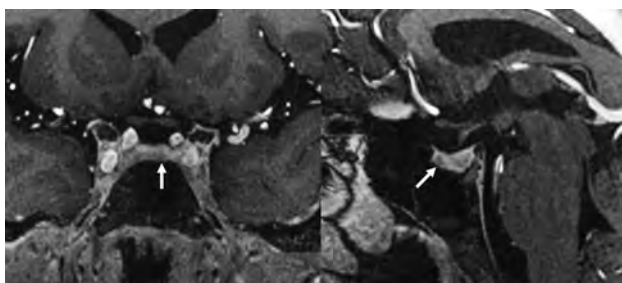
An example of 7T MR imaging showing a nondiscrete lesion (arrows) in the left paramidline pituitary gland on postcontrast MPAGE T1-weighted imaging at 0.33 mm that was a pathology-confirmed Cushing adenoma.
